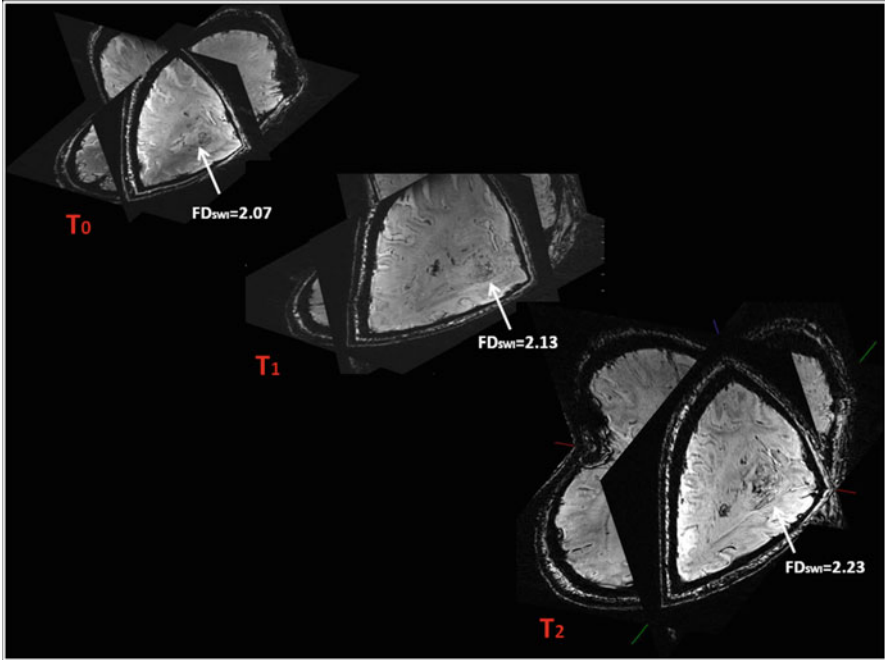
Multiplanar reconstructions of the 7 T SWI MR images in time T_0 , which were repeated serially after 2 (T_1) and 4 weeks (T_2) since the beginning of antiangiogenic treatment. The *white arrows* show the recurrence of the GBM, and from T_0 to T_2 , it is evident that there is an increase in the signal of the SWI patterns. The value of the fractal dimension of the intratumoral SWI patterns (FD_{SWI}), reported for each temporal sequence, increased over time (see text) (Reproduced from Di Ieva et al. [21] with permission of the Publisher)
